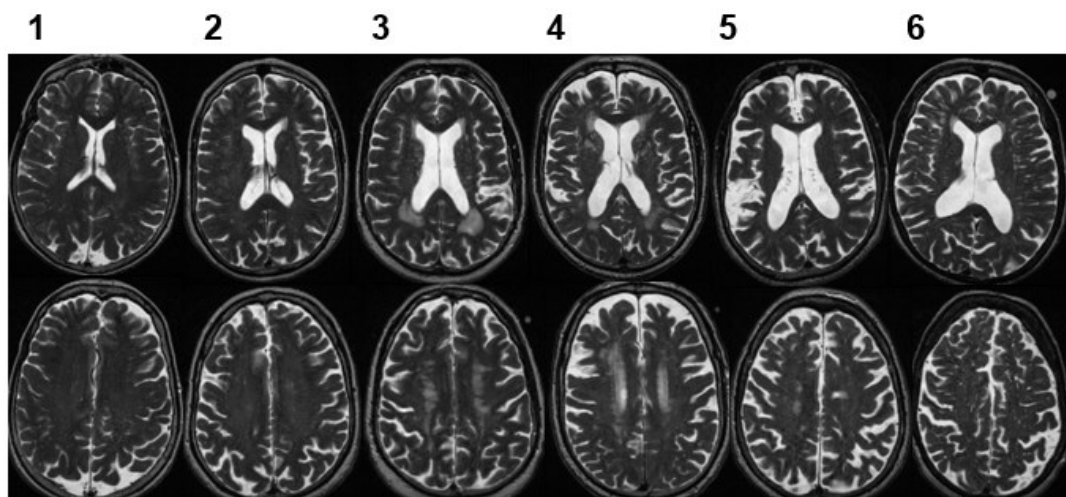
Axial T2-weighted MRI showing deep (top) and superficial (bottom) atrophy scored 1-6 based on a validated normative age template (Farrell et al., 2009). All are images of participants in the LBC 1936.
